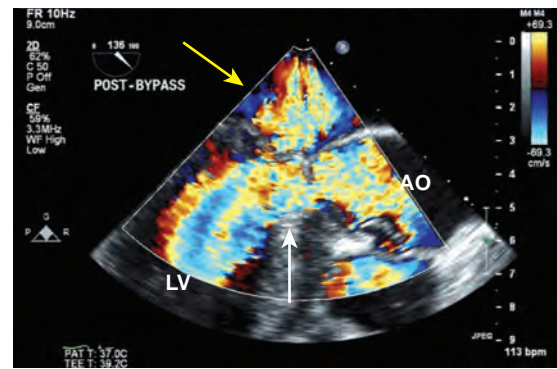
Midesophageal long-axis view reveals the left ventricular outflow tract (LVOT) after the administration of isoproterenol. The heart rate is increased, and the blood pressure is decreased. The mitral regurgitation (yellow arrow) worsens, and aliasing of the color-Doppler signal in the LVOT (white arrow) now indicates turbulence of blood flow. AO, Aorta; LV, left ventricle.
